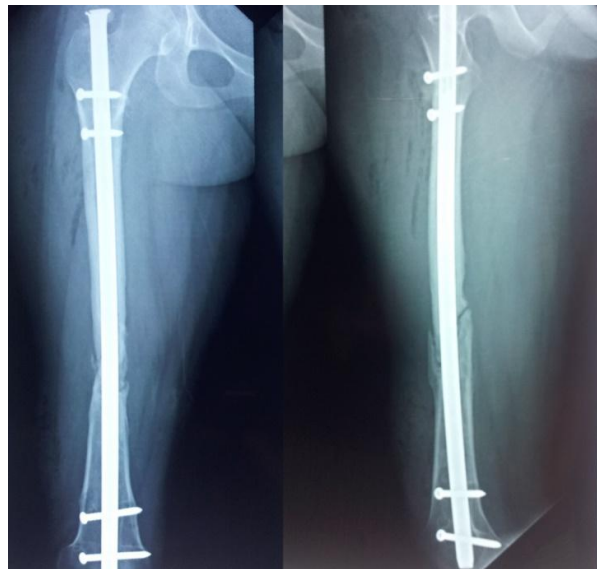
Final check radiograph showing a longer nail placed such that both the distal locking bolts are beyond the cortical window
